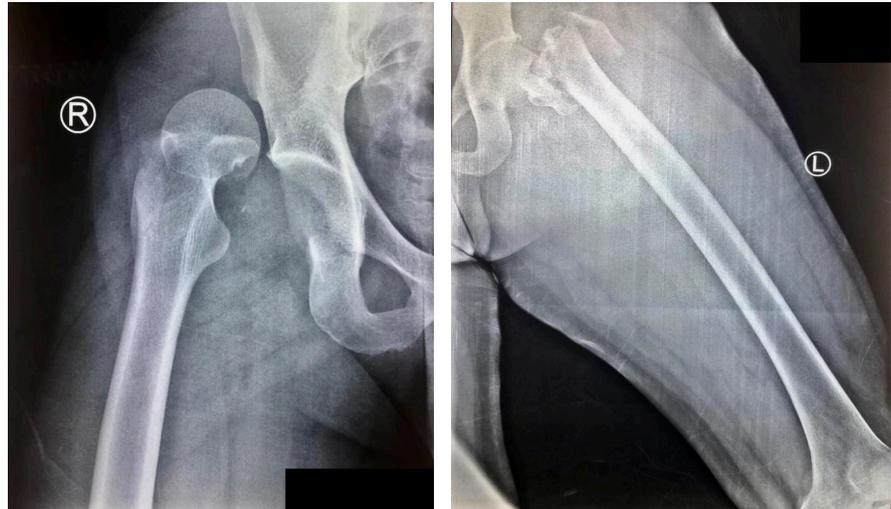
Plain AP radiograph of right hip showing posterior hip dislocation with greater trochanter avulsion (left) and comminuted left intertrochanteric fracture (right).
